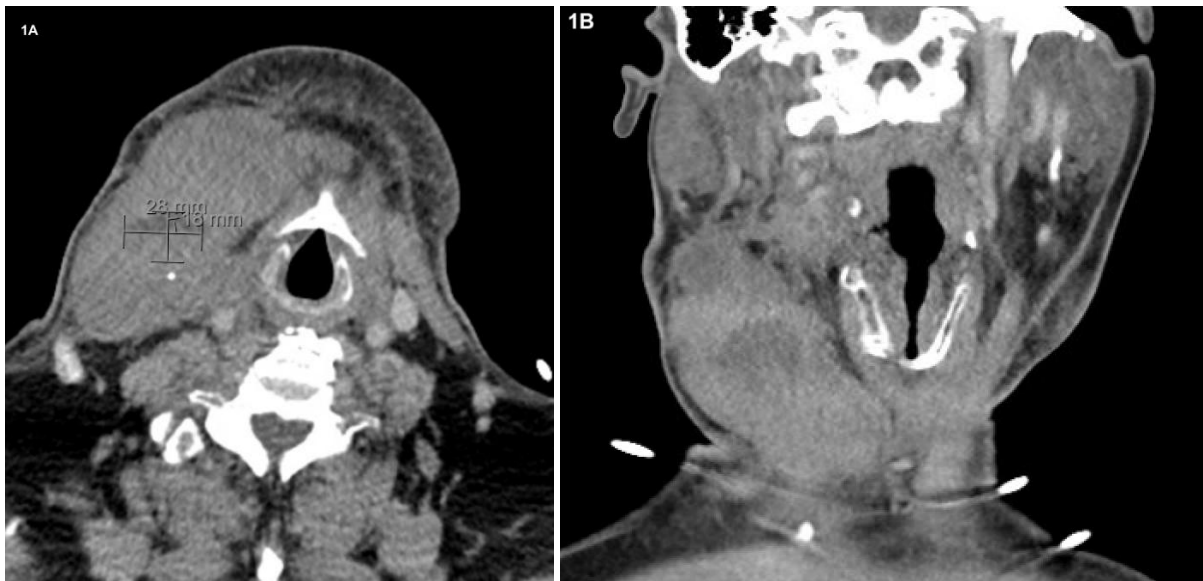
CT angiogram of the neck demonstrating delayed post-thyroidectomy haematoma. (A) axial contrast-enhanced CT image showing a 105 mm right anterior neck haematoma with fluid filled level (28x18 mm, arrows) indicating active or recent bleeding, (B) coronal contrast-enhanced CT image showing the right anterior neck haematoma with mild leftward midline shift of the trachea. No active contrast extravasation was identified, and the airway remained patent without significant compression.
